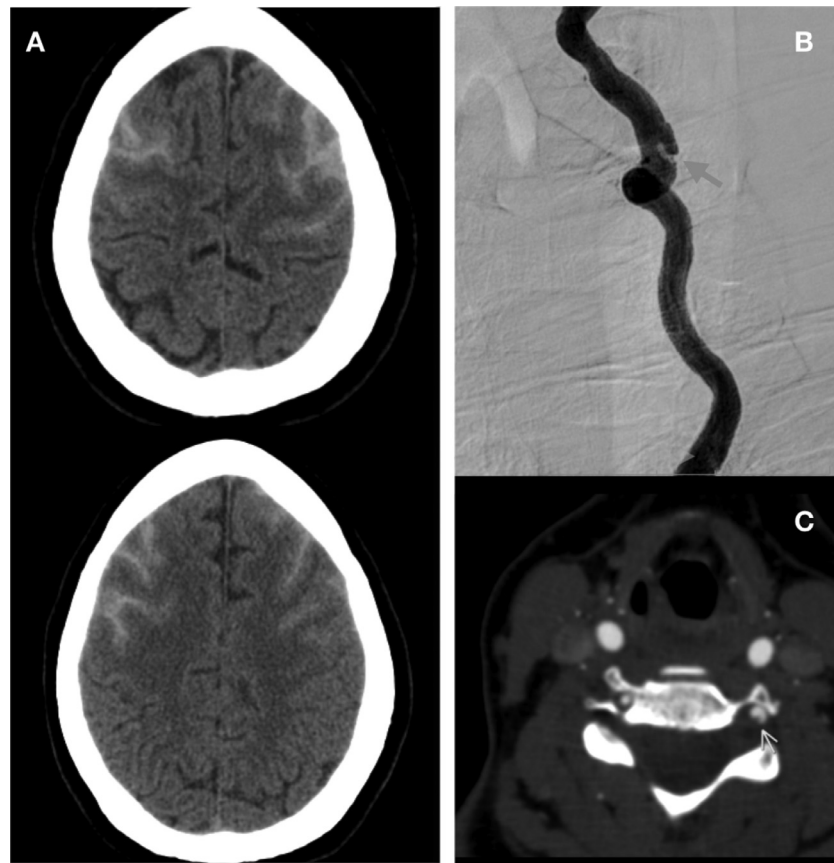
CT brain on admission demonstrates bilateral convexity subarachnoid hemorrhage (A); diagnostic cerebral angiogram on admission demonstrates a left vertebral artery dissection (B), also seen on CT angiogram (C).
